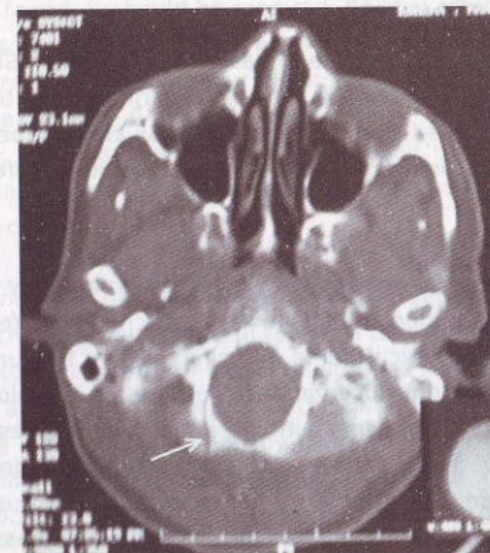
CT scan showing fracture of foramen magnum on right side (type of skull base fracture)
